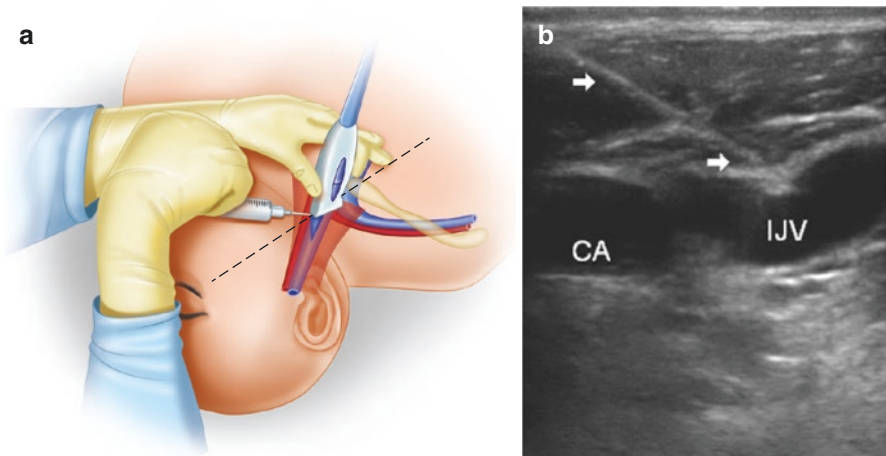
(a) Medial puncture of the jugular vein with the probe in a position oblique to the vein and parallel to the needle. (b) Corresponding ultrasound image. CA—carotid artery; IJV—internal jugular vein; white arrows—puncture needle
